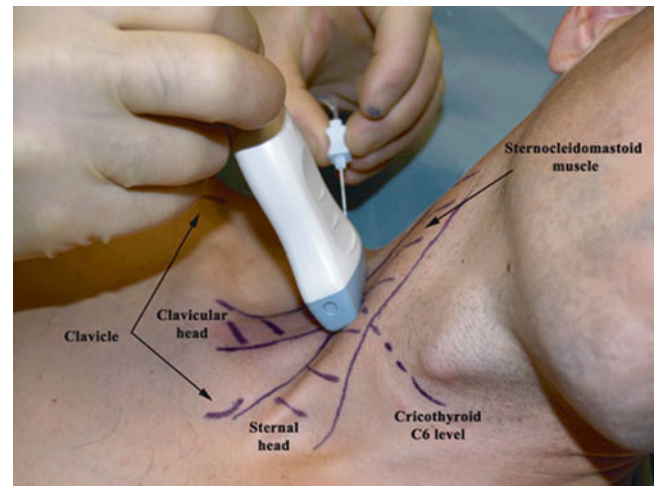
Ultrasound-guided interscalene brachial plexus block (With permission from Buckenmaier and Bleckner [71])
